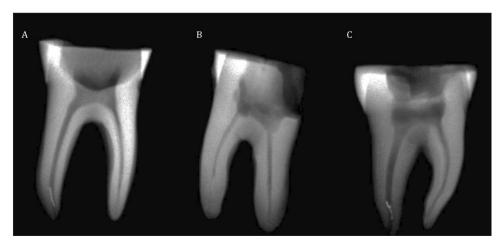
Radiographic images (A-C) of fractured instruments in the root canal after exploration with Wave One Gold Glider (A-B) and R-Pilot (C)
